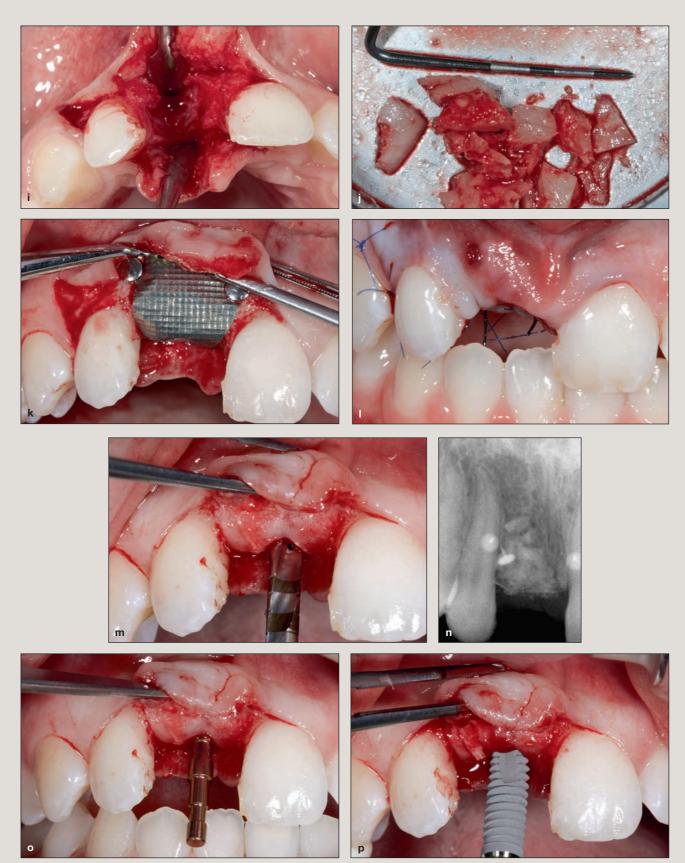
cont. / (i) Occlusal view of the defect. (j) Autogenous bone graft from the right retromolar region. (k) Augmented area with laser-perforated titanium membrane fixed with titanium pins. (l) Condition immediately after augmentation. Only one relieving incision was placed distal to the distal adjacent tooth. (m) After reopening and removal of the titanium membrane, regenerated alveolar ridge 3 months after augmentation can be observed. (n) Radiograph after augmentation. (o) Paralleling pin in place. (p) Placement of a 3.8-mm-diameter implant.
